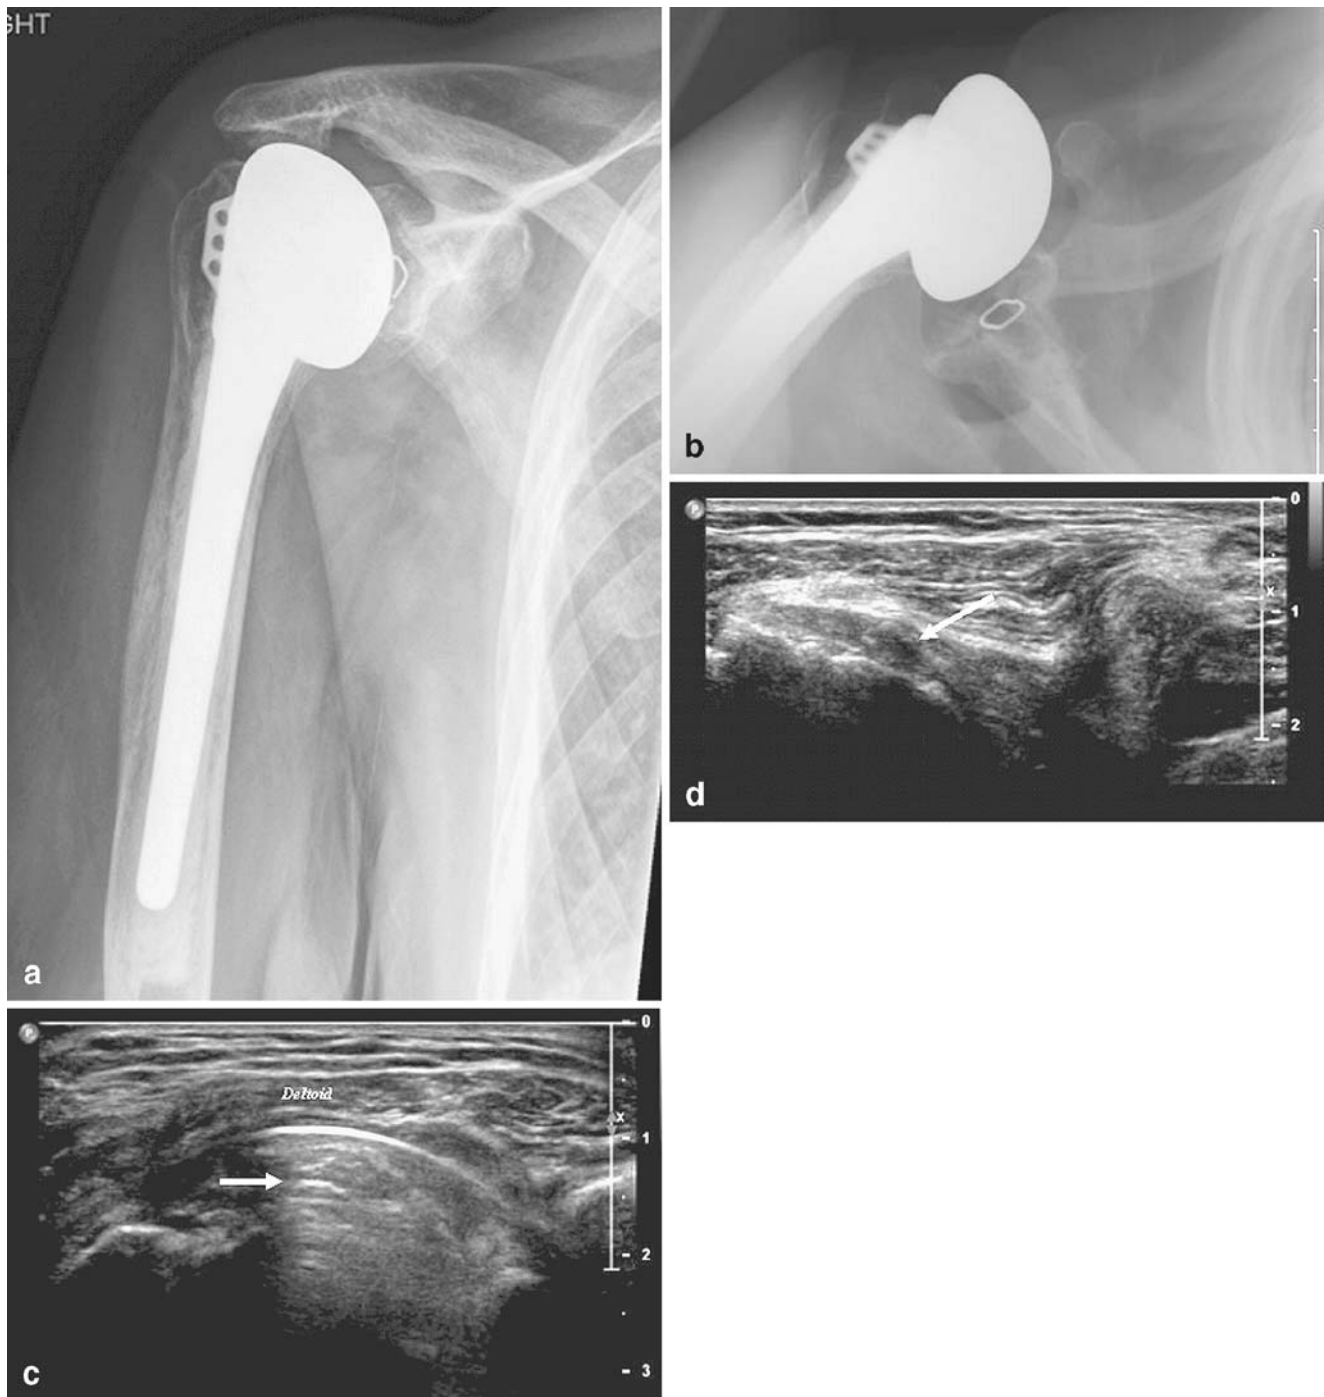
69-year-old female 4 years status post total shoulder arthroplasty with pain and limited range of motion. a Externally rotated radiograph of the right shoulder demonstrates superior migration of the metallic humeral head. b Axillary view demonstrates relative anterior subluxation of the humeral head suggesting subscapularis insufficiency. c Longitudinal ultrasound image demonstrates superior migration of the metallic humeral head with characteristic reverberation artifact (*white arrow*). Direct apposition of the humeral head to the undersurface of the deltoid (*labeled*) is consistent with chronic rotator cuff insufficiency. d Transverse ultrasound image in the same patient demonstrates a markedly degenerated subscapularis tendon with a high-grade partial, essentially complete, degenerative tear of the deep fibers of the subscapularis (*arrow*)
